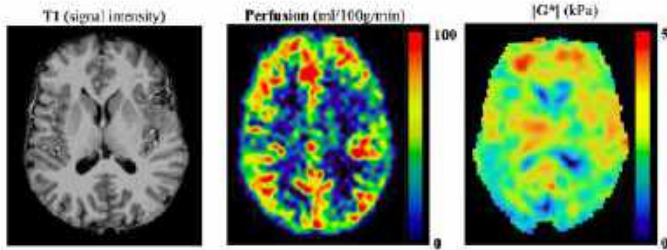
Exemplary axial slice of T1-weighted signal intensity image, perfusion map in ml/100g/min, and elastogram in kPa.
